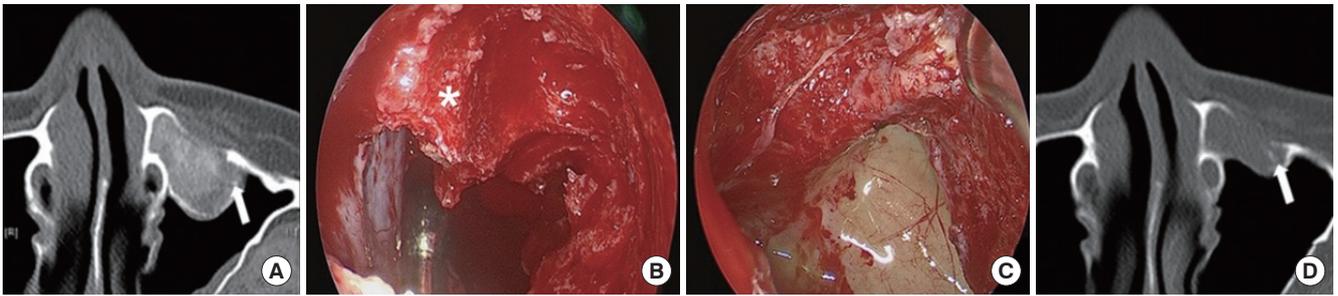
Ossifying fibroma excision case using endoscopic prelacrimal medial maxillectomy. (A) Fibro-osseous lesion in the anterior wall of the left maxillary sinus shown on preoperative computed tomography (CT) scan (arrow: infraorbital nerve). (B) Bony tumor in the maxillary sinus anterior wall encasing the infraorbital nerve (asterisk). (C) Decompressed infraorbital nerve was defined. (D) Postoperative 6-month CT scan showed removal of bony tumor and only a small amount of soft-tissue lesion remaining (arrow: infraorbital nerve).
